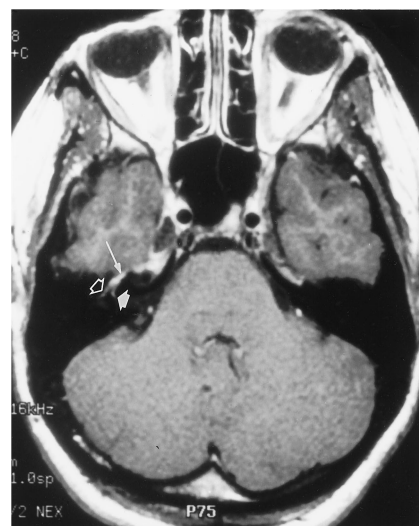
Ramsay Hunt syndrome (herpetic neuralgia). Axial contrast-enhanced T1-weighted MR image (625/25/2) shows intense enhancement of the labyrinthine (*thick solid arrow*) and tympanic (*open arrow*) portions of the right facial nerve and of the GSPN (*long arrow*).
